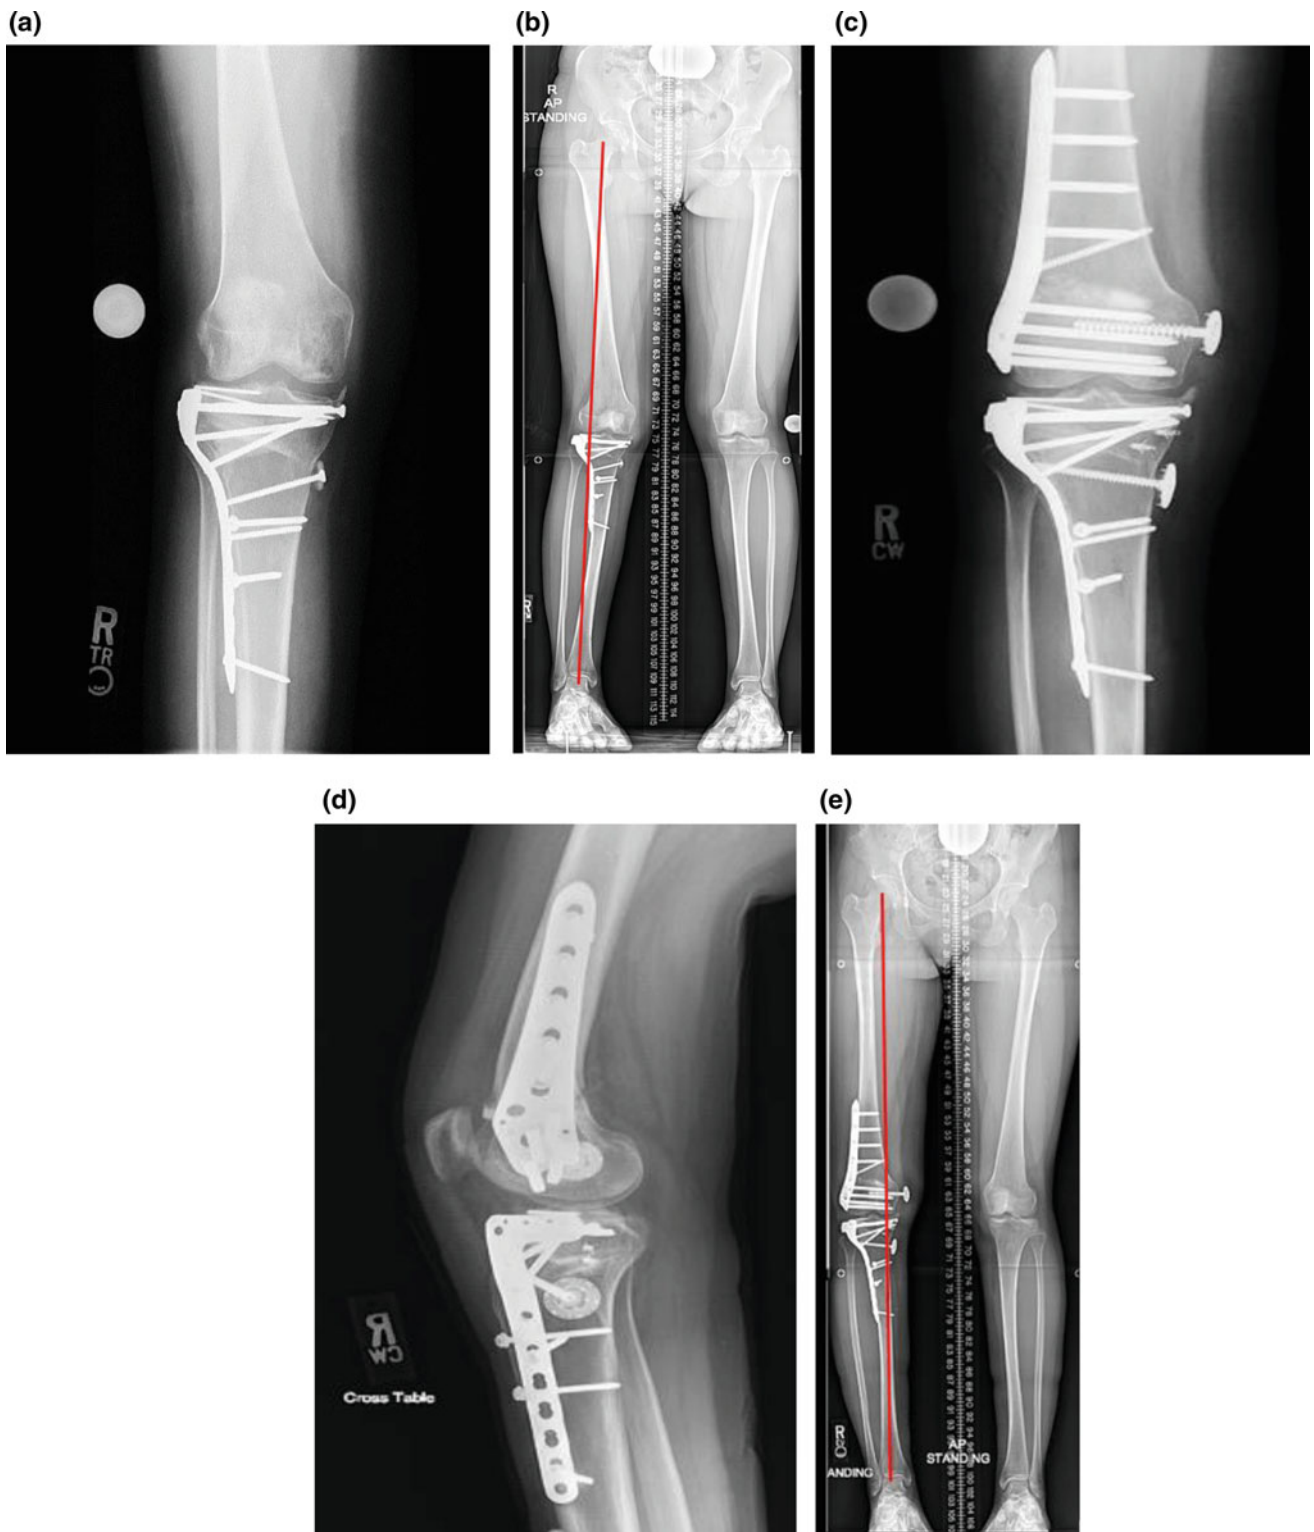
Twenty-one-year-old female status post tibial plateau ORIF and MCL repair now with medial insufficiency. a Pre-DFO AP radiograph right knee; b Pre-DFO standing bilateral radiograph HKA; c Post-DFO and MCL reconstruction AP radiograph right knee; d Post-DFO and MCL reconstruction lateral radiograph right knee; e Post-DFO and MCL reconstruction standing bilateral HKA
